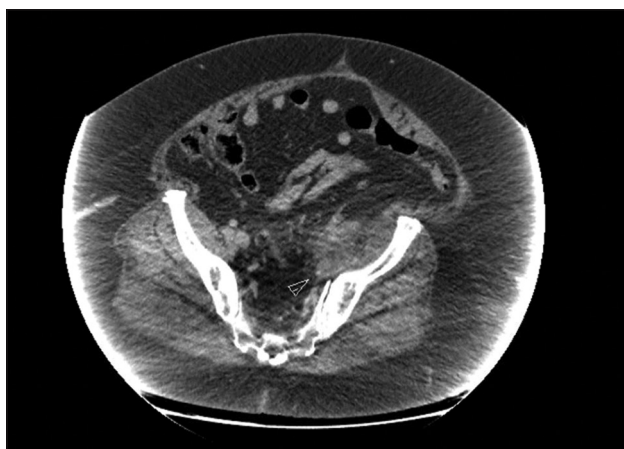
Abdomen/pelvis computed tomography showing a mass along the left pelvic sidewall, which is partially encasing and narrowing the left external iliac artery and inseparable from the left psoas, iliacus, and obturator internus muscles.
